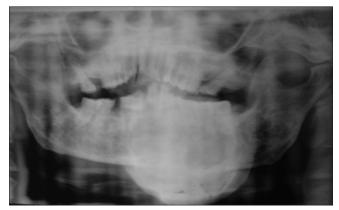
Preoperative OPG radiograph
